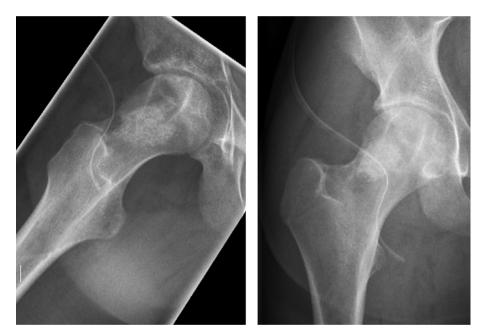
The postoperative radiographs show defect reconstruction with bone substitute.
